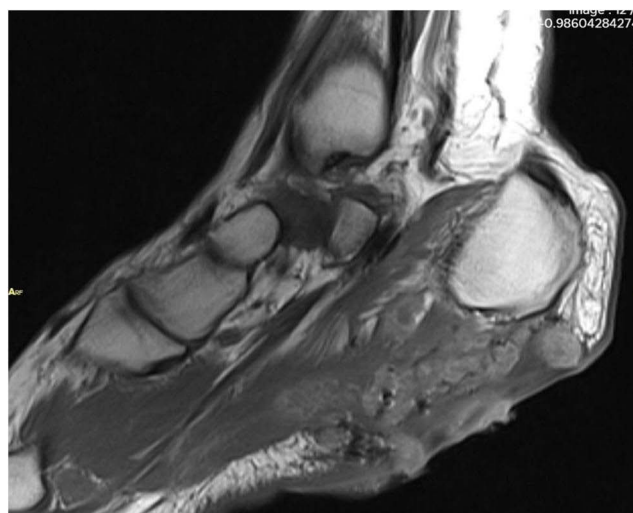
Magnetic Resonance Imaging (MRI) of the right foot (Sagittal and Coronal views) demonstrating extensive soft tissue involvement. Arrows indicate the “dot-in-circle” sign, which is characteristic of mycetoma.
